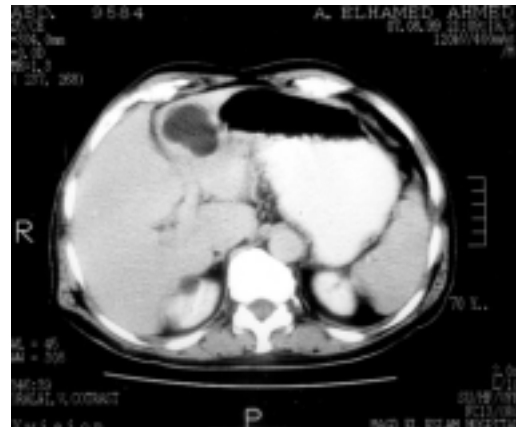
Post contrast axial CT scan of the liver revealed a relatively well defined hypodense, cystic lesion implicating the lateral segment of the left lobe yet no definite demarcated capsule is noted.
